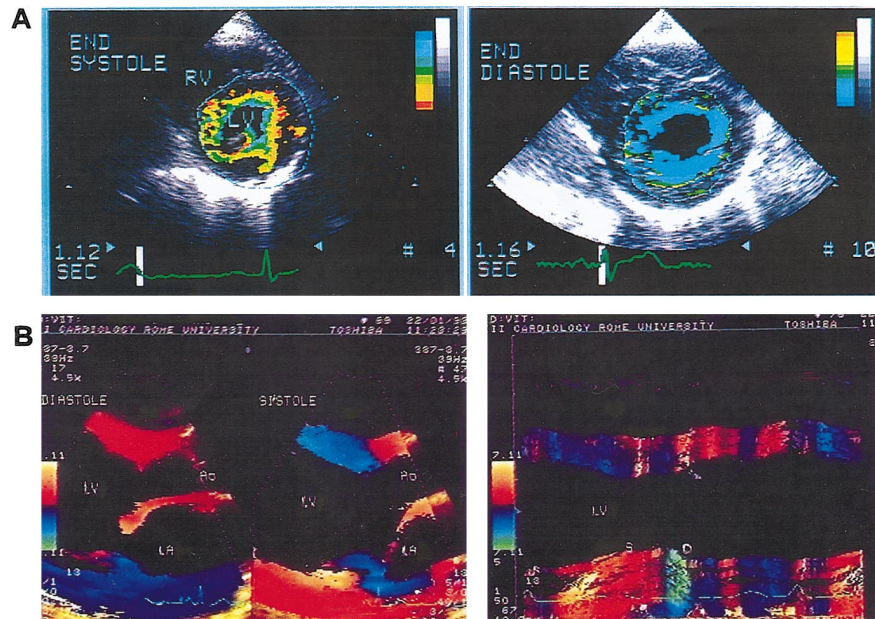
(A) Color kinesis images obtained in the parasternal short-axis view at end-systole and end-diastole. From early systole to end-systole (*left*) and from early diastole to end-diastole (*right*), an increasing number of colors is added with progressive inward and outward endocardial excursion. (B) Tissue Doppler image, M-mode (*right*), and parasternal long-axis view (*left*) of the left ventricle (LV), showing the distribution of color-coded myocardial velocities and the normal contraction and relaxation pattern of septal and posterior wall in systole "S" and diastole "D." Motion toward the transducer is color-coded red and motion away from the transducer is color-coded blue.
